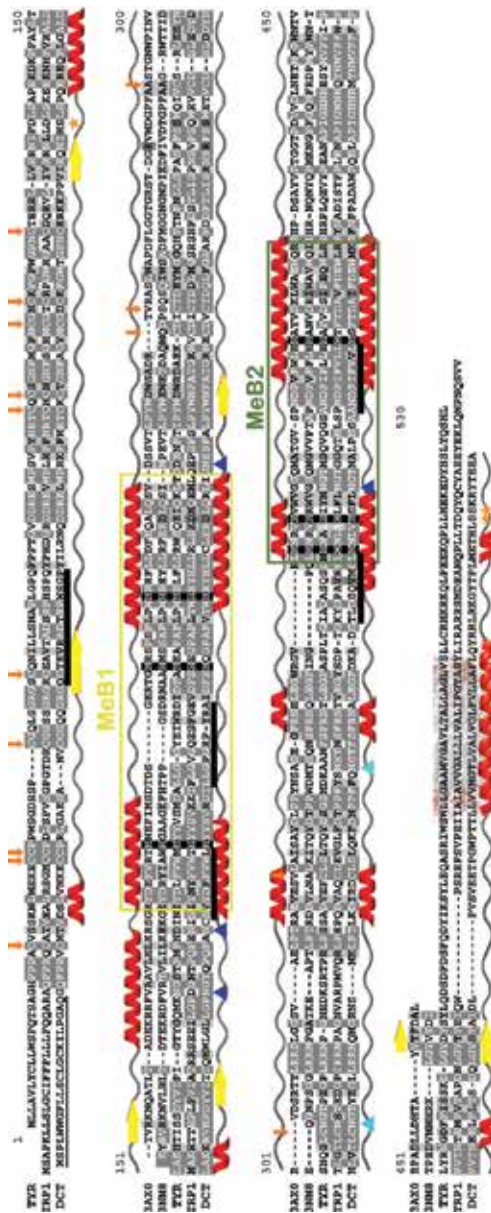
Sequence alignment of human TRPs (TYR, TRP1, and DCT) with the X-ray templates used for modeling DCT (PDB codes 3AX0 and 3NM8). Identical/similar residues between DCT and other sequences are highlighted dark/light gray, metal binding His residues are highlighted black. Assigned/predicted secondary structure elements for templates/DCT are shown above and below the alignment. Membrane pictogram indicates location of (predicted) transmembrane region in all proteins. The rectangles indicate the two Metal-binding regions (MeB1, MeB2). Symbols indicate various functionally relevant residues: stars = phosphorylated residues; diamond = methylated R409 residue; dark triangles = putative N-glycosylation sites, light triangles = experimentally confirmed occupied sites in DCT; arrows = Cys residues. Signal sequence in DCT is thin underlined. The DCT-derived peptides 60–74 [18], 180–188 [19], 197–206 [20], 360–368 [21], 387–395 [22] recognized by CD4+ or CD8+ T-lymphocytes are indicated by thick lines.
